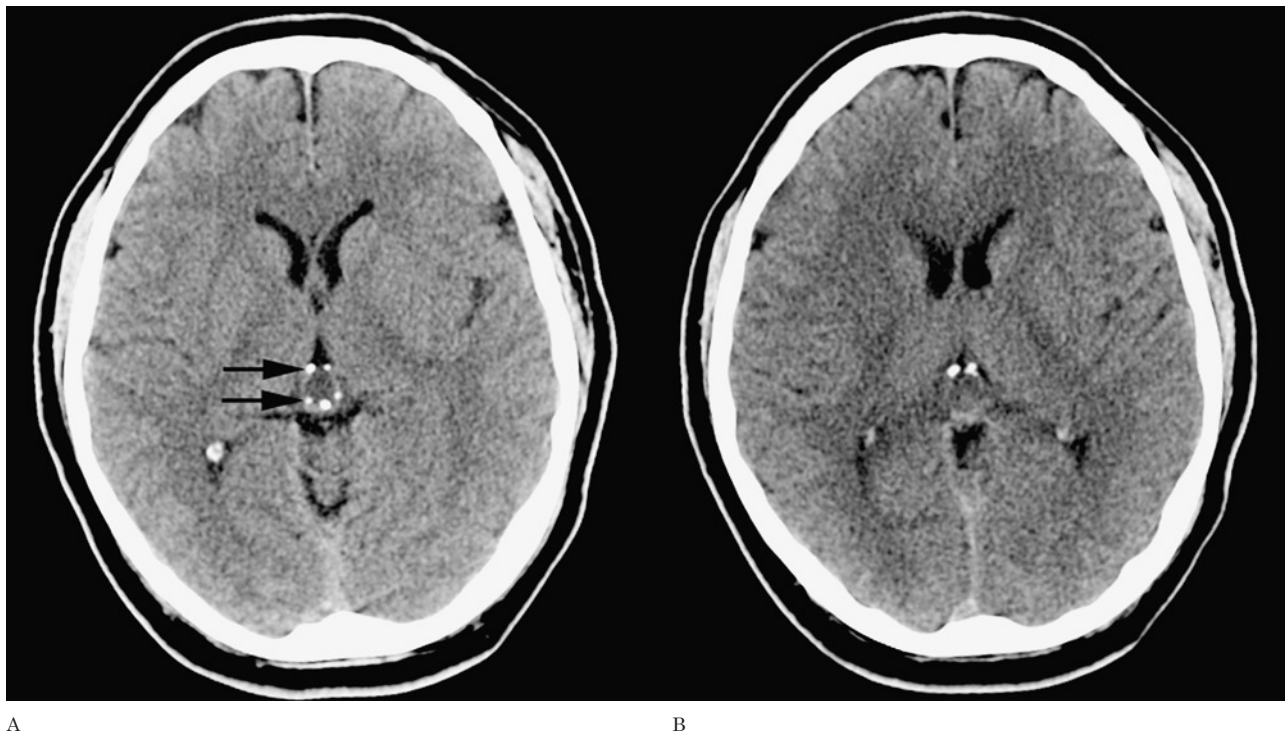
Pineocytoma. Non-contrast CT images (A,B) demonstrate the typical 'exploded' peripheral calcifications (arrows) in this well circumscribed hypodense mass arising from the pineal region. There is no hydrocephalus. The patient had presented with Parinaud syndrome.
